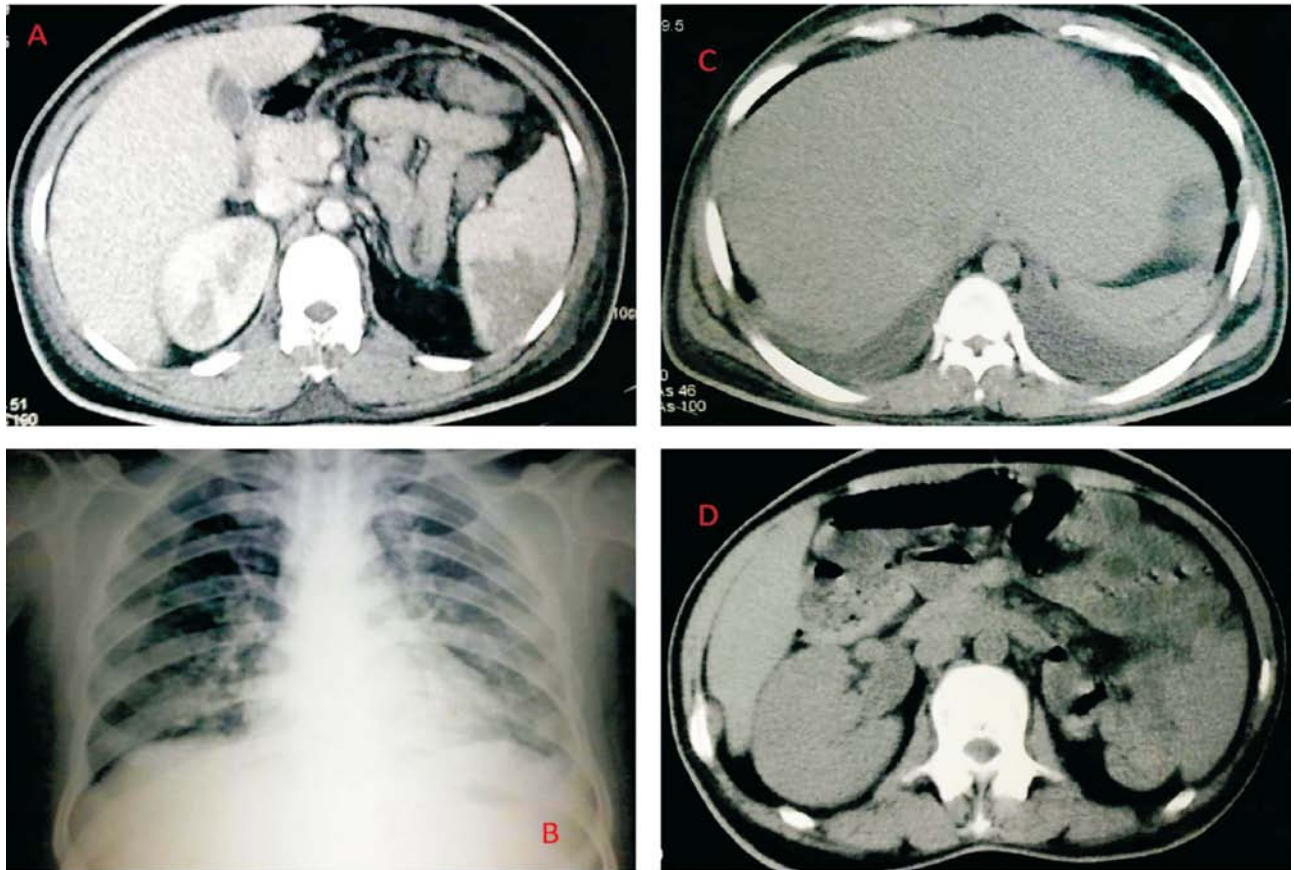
CT examination I.
